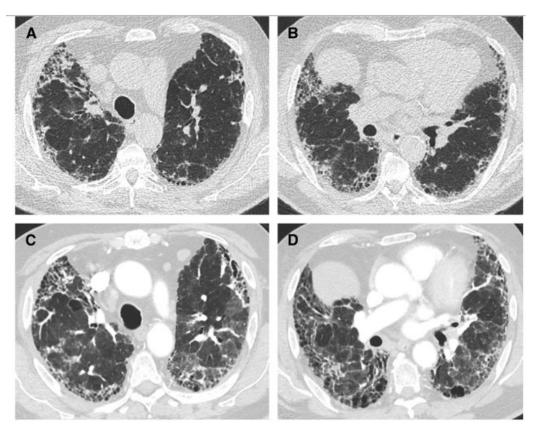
Acute exacerbation of IPF. (A,B). Transverse computed tomography sections obtained in the upper and mid lung zones and (C,D) during acute exacerbation showing newly developed, bilateral ground glass opacification in both lungs on a background of usual interstitial pneumonia pattern. Picture obtained from Raghu et al. [6].
